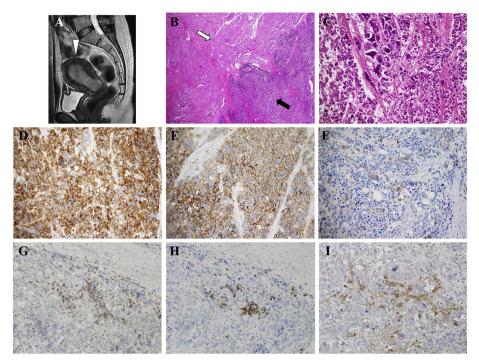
Pelvic MRI findings and results of pathology in uterus carcinoma
